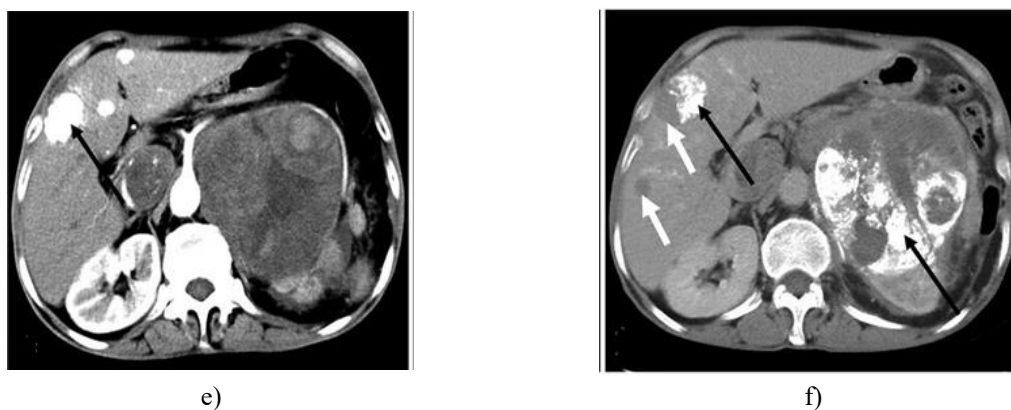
DSA and CECT images: (a–c) DSA of abdominal vessels shows the left inferior phrenic artery (a: black arrows), branches of the left adrenal artery (c: black arrows), and the proper hepatic artery (b: black arrows) were thickened, seem to be tortuous, and are involved in the blood supply of the left sub-diaphragmatic, retroperitoneal, and intrahepatic tumors, respectively. d, e, f: CECT shows high-density shadow deposition in the left sub-diaphragmatic (d: black arrows), retroperitoneal (fig. f black arrows), and intrahepatic (fig. e black arrows) lesions after TACE and increased and enlarged intrahepatic metastases (f white arrows). Abbreviations: CECT = contrast-enhanced computed tomography; DSA = digital subtraction angiography; TACE = transarterial chemoembolization.
